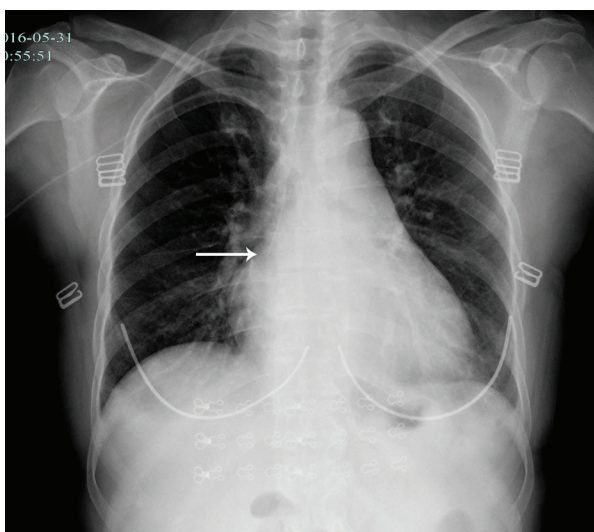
Postero-anterior chest radiograph demonstrating the tip location (white arrow) of the PICC line near the superior cavo-atrial junction.
